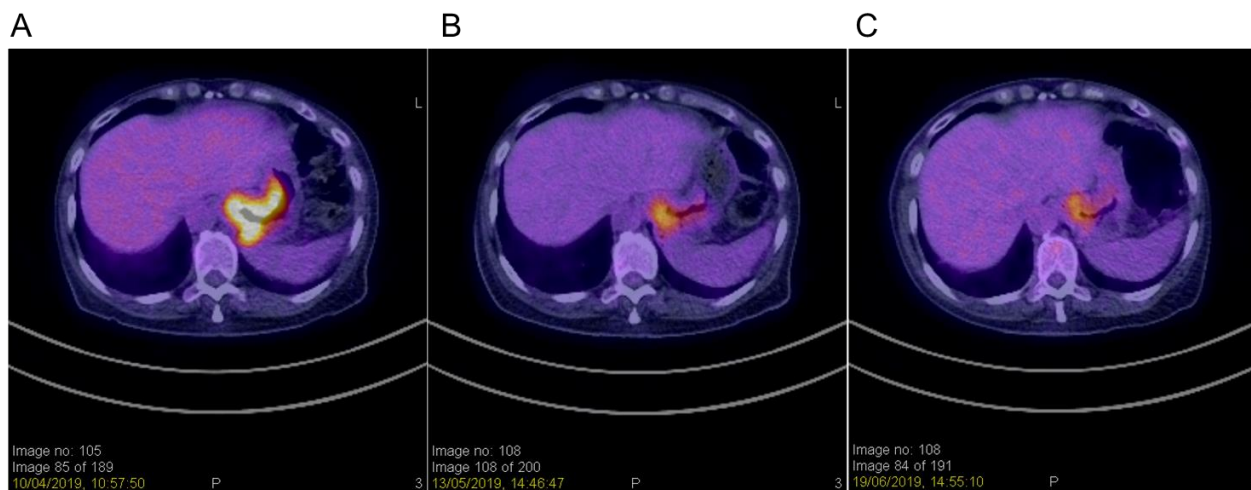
Images of sequential PET-CT scanning of iMYC patient at protocol-mandated timepoints of (A) screening, (B) day 14 and (C) week 8 ibrutinib treatment.
